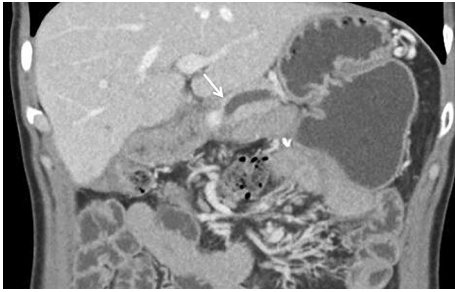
46-year-old woman with history of pancreatic divisum and chronic pancreatitis who underwent a pylorus-preserving Whipple procedure. Post-operative CT obtained 6 months later shows ductal dilation of the remnant pancreas indicative of a structure.
